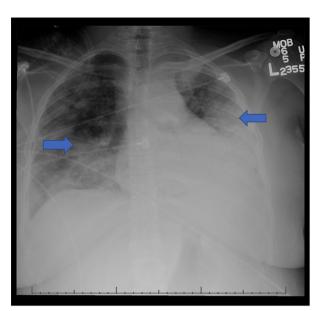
Chest X-ray showing extensive bilateral pleural effusions (arrows), worse on the left, with a differential diagnosis of pulmonary edema versus multifocal pneumonia.
